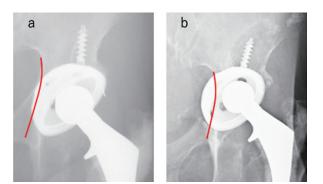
Case 1. Anteroposterior radiographs of the left hip at 5 (a) and 20 (b) years after the primary surgery. Polyethylene wear progressed and the cup gradually protruded into a defect in the medial wall of the pelvis (red line).
